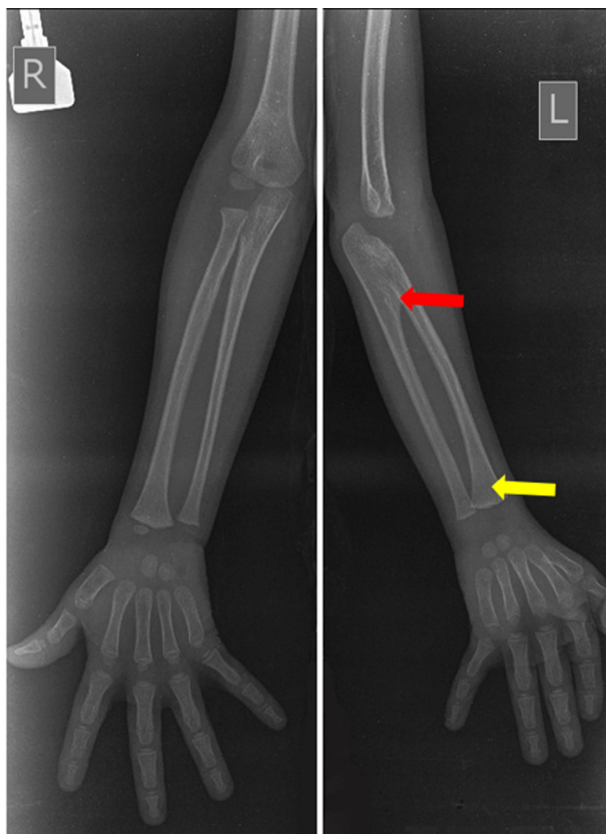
AP radiographs showing both elbows; radius and ulna bones; and both wrists and hands bones with a comparatively shorter left radius and ulna. It also shows fused proximal quarter (red arrow) but normal distal 3 quarters of the left radius and ulna bones with a normal left distal radioulnar joint (yellow arrow).
